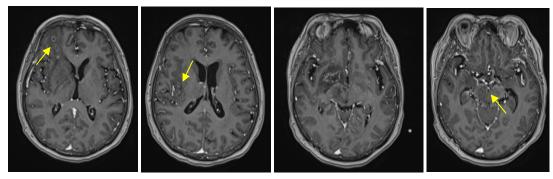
MRI Brain axial images post gadolinium on admission showing multiple rim-enhancing lesions at the right frontal, temporal, basal ganglia and right ventromedial midbrain with white matter oedema causing mild midline shift.
